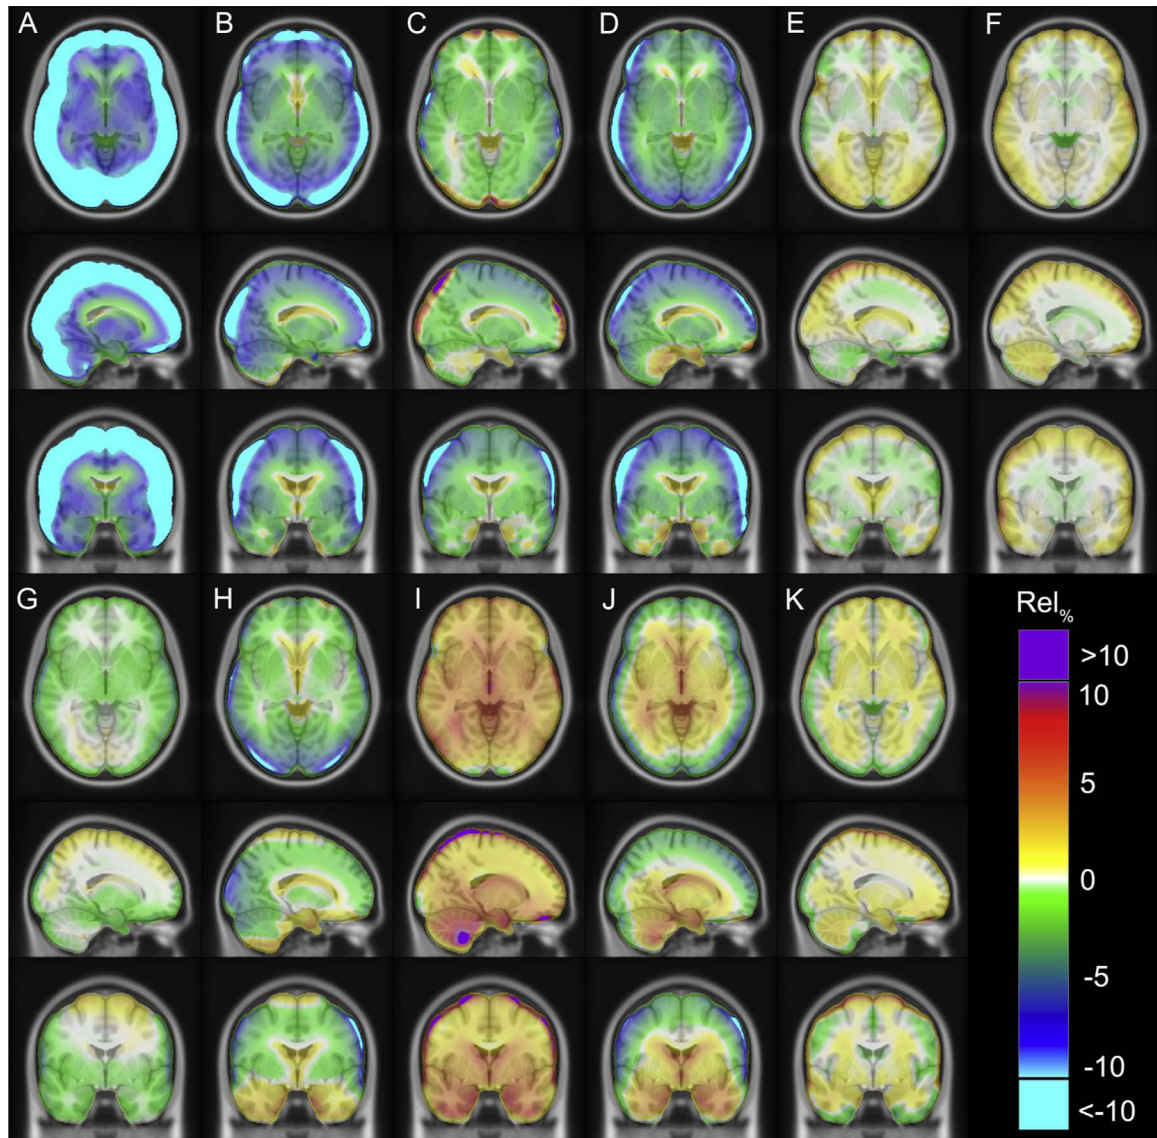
Averaged $Rel_{\%}$ images across all FDG patients ($n=201$, including patients with fat/water tissue inversion) for each method: (A) Dixon, (B) UTE, (C) Segbone, (D) Ontario, (E) Boston, (F) UCL, (G) MaxProb, (H) MLAA, (I) Munich, (J) CAR-RiDR, (K) RESOLUTE.
